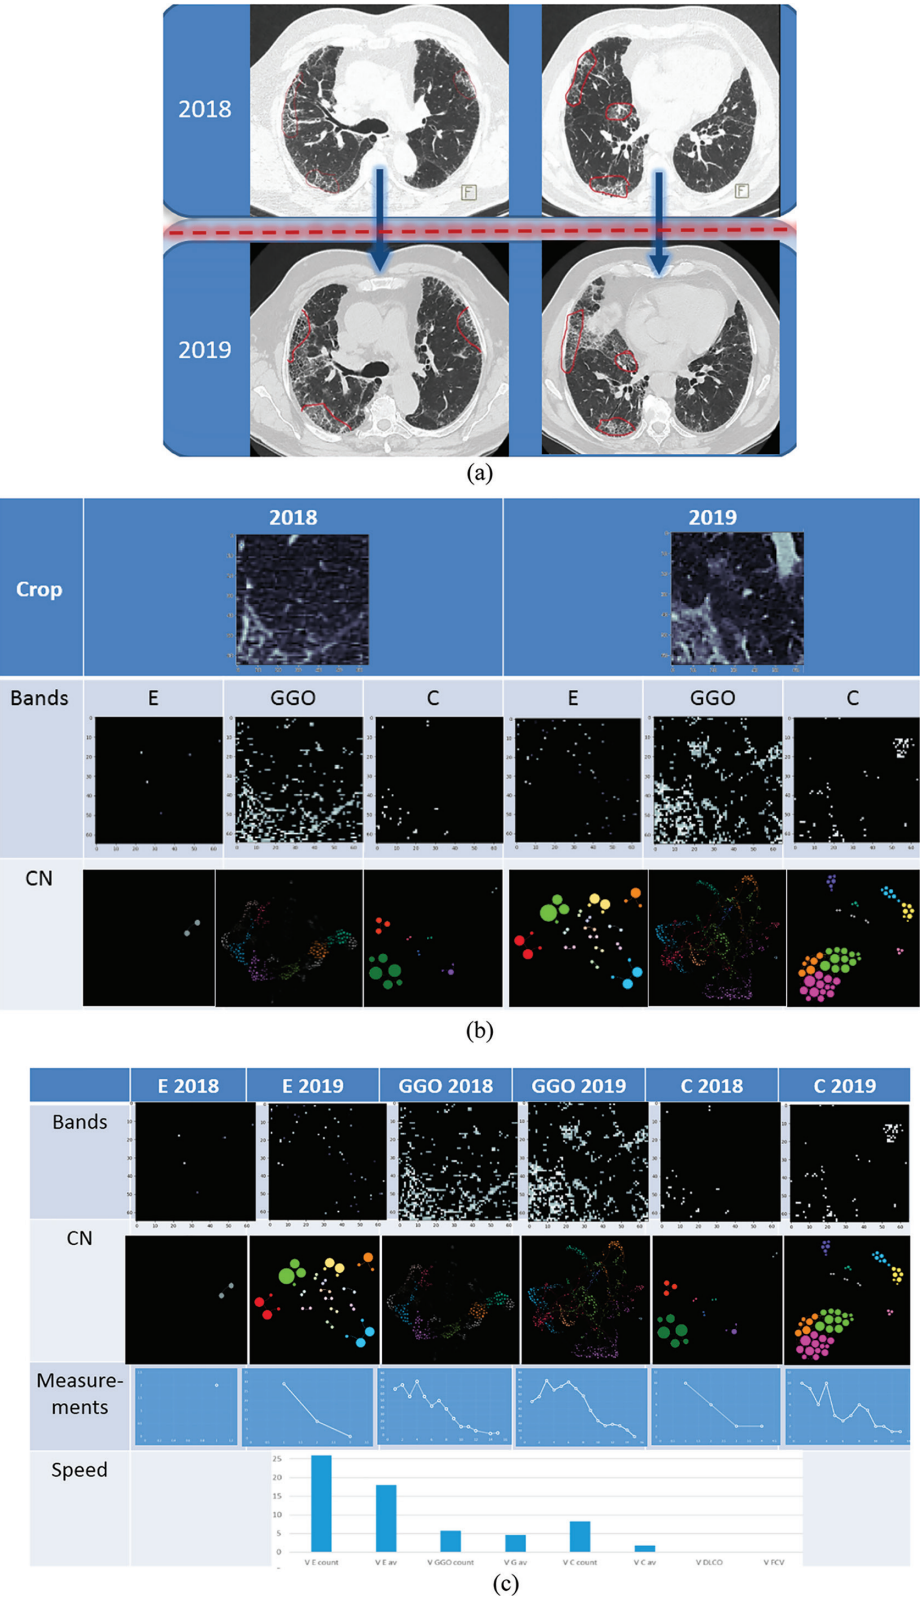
NSIP patient evaluation using the CN technique (a) Relevant axial HRCT slices showcasing progression (b) Region of interest selected from the same location, split into the three layers and the generation CN (c) Dynamic CN evaluation by using the relative speed for each layer.
